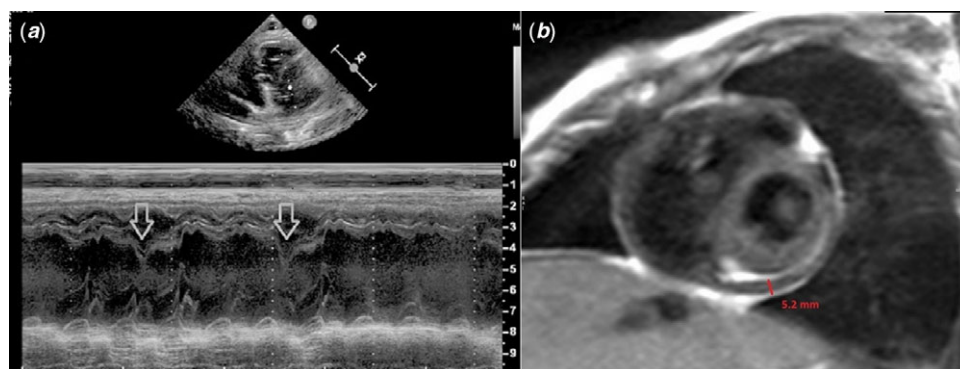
(a) Septal bouncing on m-mode echocardiography and (b) thickened pericardium seen in cardiac MRI.
